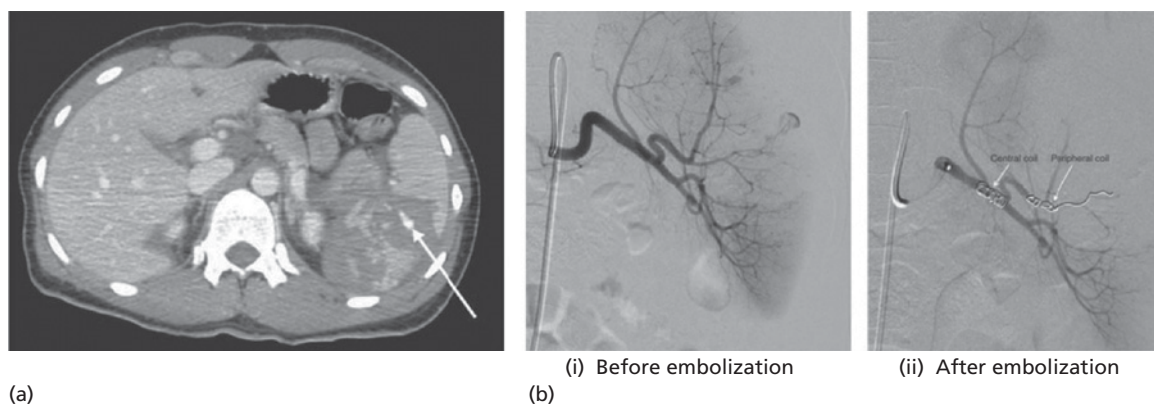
(a) Computed tomogram showing splenic injury (Organ Injury Scale grade 4) with contrast extravasation (white arrow) (b) Angiography (i) with signs of ongoing bleeding before embolization and (ii) after distal and proximal embolization. (Source: Skattum *et al.*, 2012. Reproduced with permission of John Wiley & Sons.)
